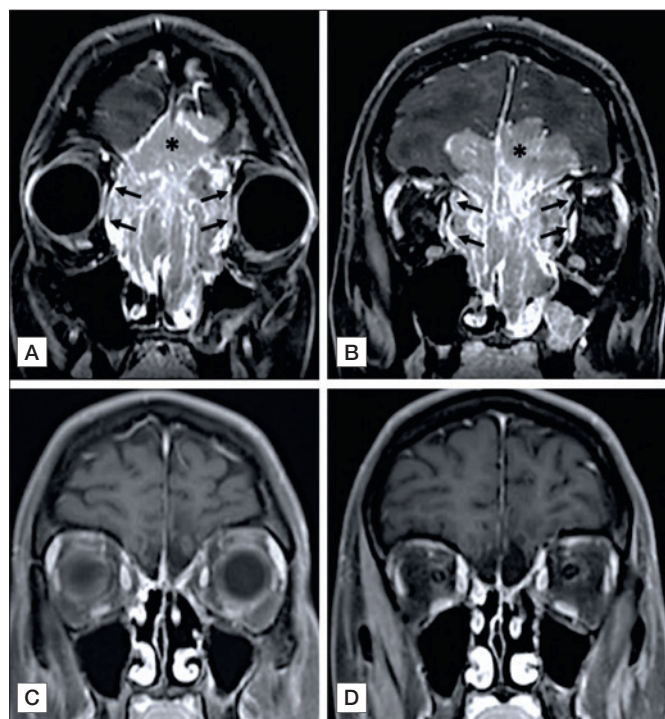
Contrast-enhanced MRI in coronal views (panels A and B) of a 30 year-old female affected by poorly-differentiated small cells neuroendocrine carcinoma, with intracranial involvement (black asterisk) and bilateral orbital invasion (black arrows). The patient received induction chemotherapy (cisplatin/etoposide scheme, 5 cycles) with complete response. The patient was therefore submitted to exclusive chemoradiation with curative intent. The contrast-enhanced MRI performed 2 years after treatment excluded recurrences of disease (C and D).
